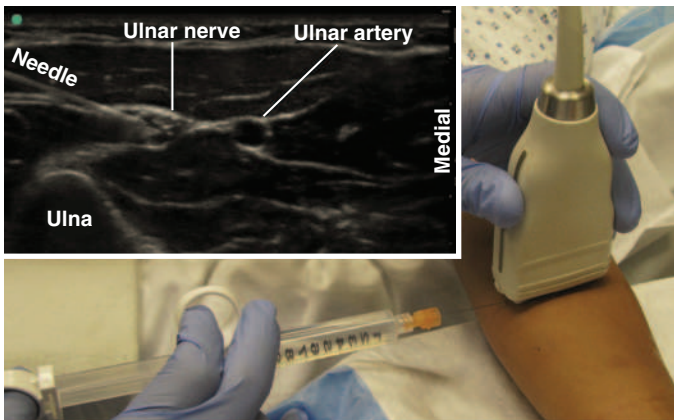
Ultrasound-guided ulnar nerve block. The ulnar nerve is identified on the ulnar aspect of the volar surface of the midforearm as an hyperechoic, honeycomb structure traveling just lateral to the ulnar artery and just deep to the superficial flexor muscles. In this example, it is being targeted using an in-plane approach.
